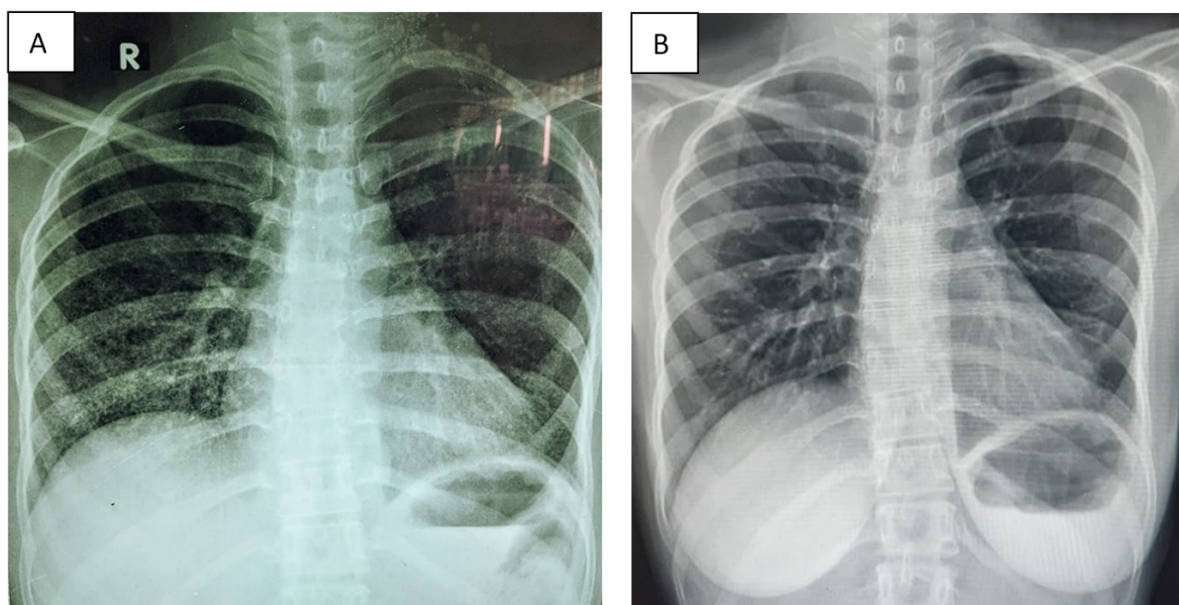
Chest radiograph (A) at admission; (B) at 10 weeks of antituberculosis treatment.
